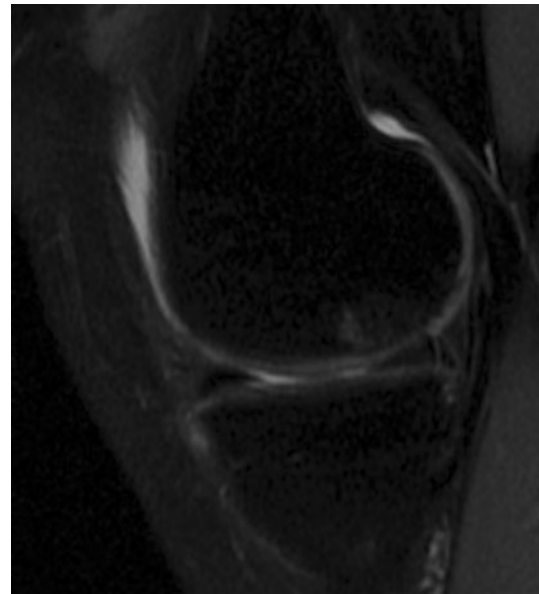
Postoperative magnetic resonance imaging. Coronal view of the same patient at 24 months of follow-up
